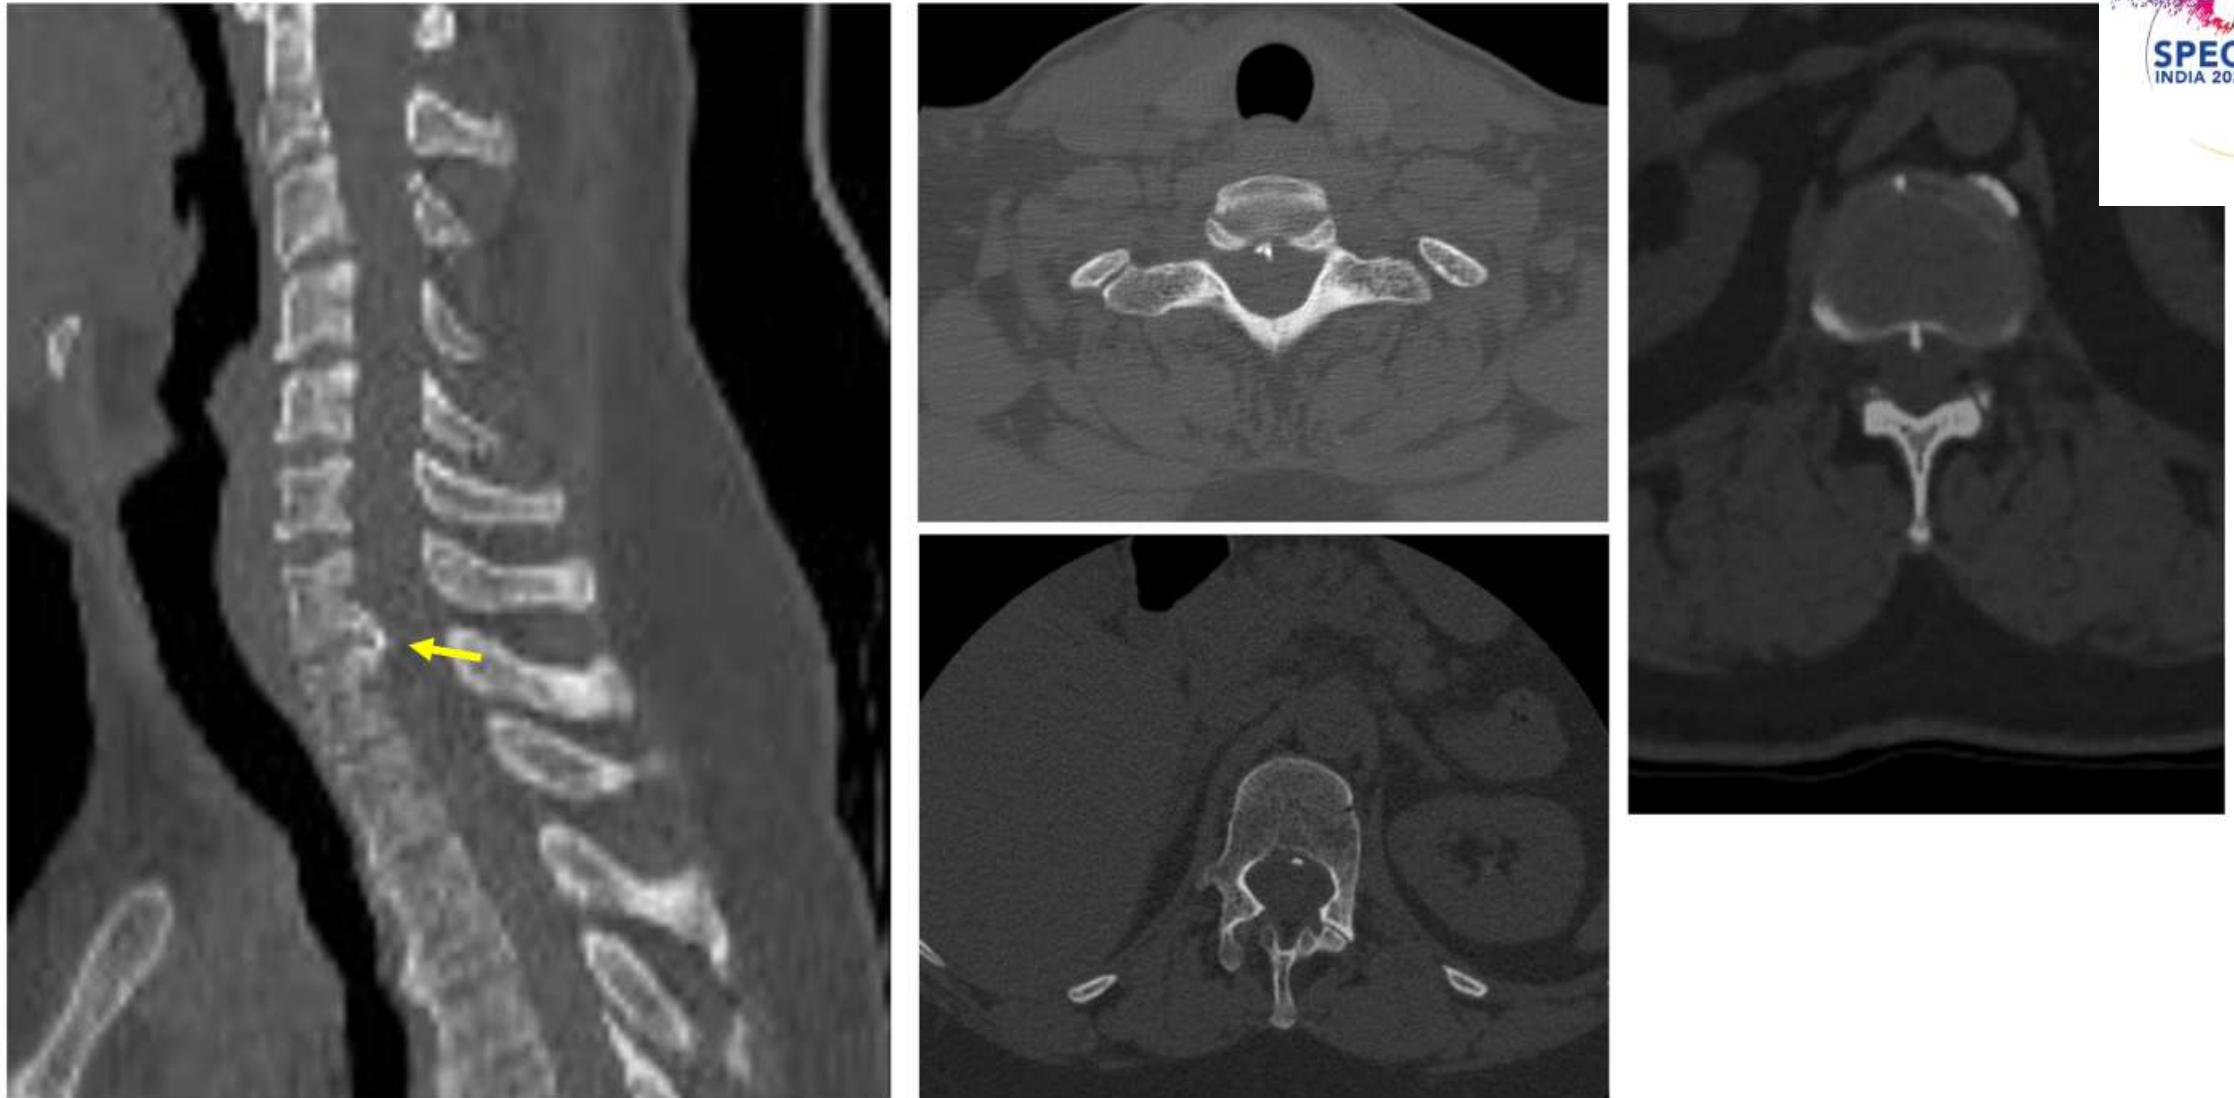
Plain CT of the spine shows calcified disc protrusions or osteophytes which are commonly the cause of dural tears and CSF leak which can be identified with CT myelography.
